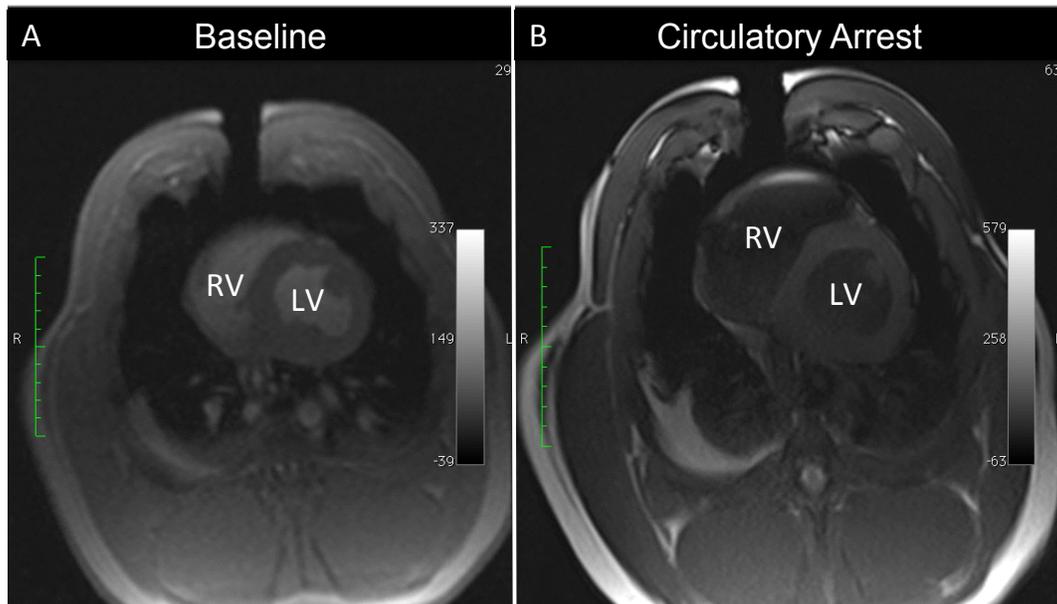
Magnetic resonance images demonstrating right and left ventricular volumes A) at baseline prior to cessation of mechanical ventilation and B) after declaration of circulatory arrest.
